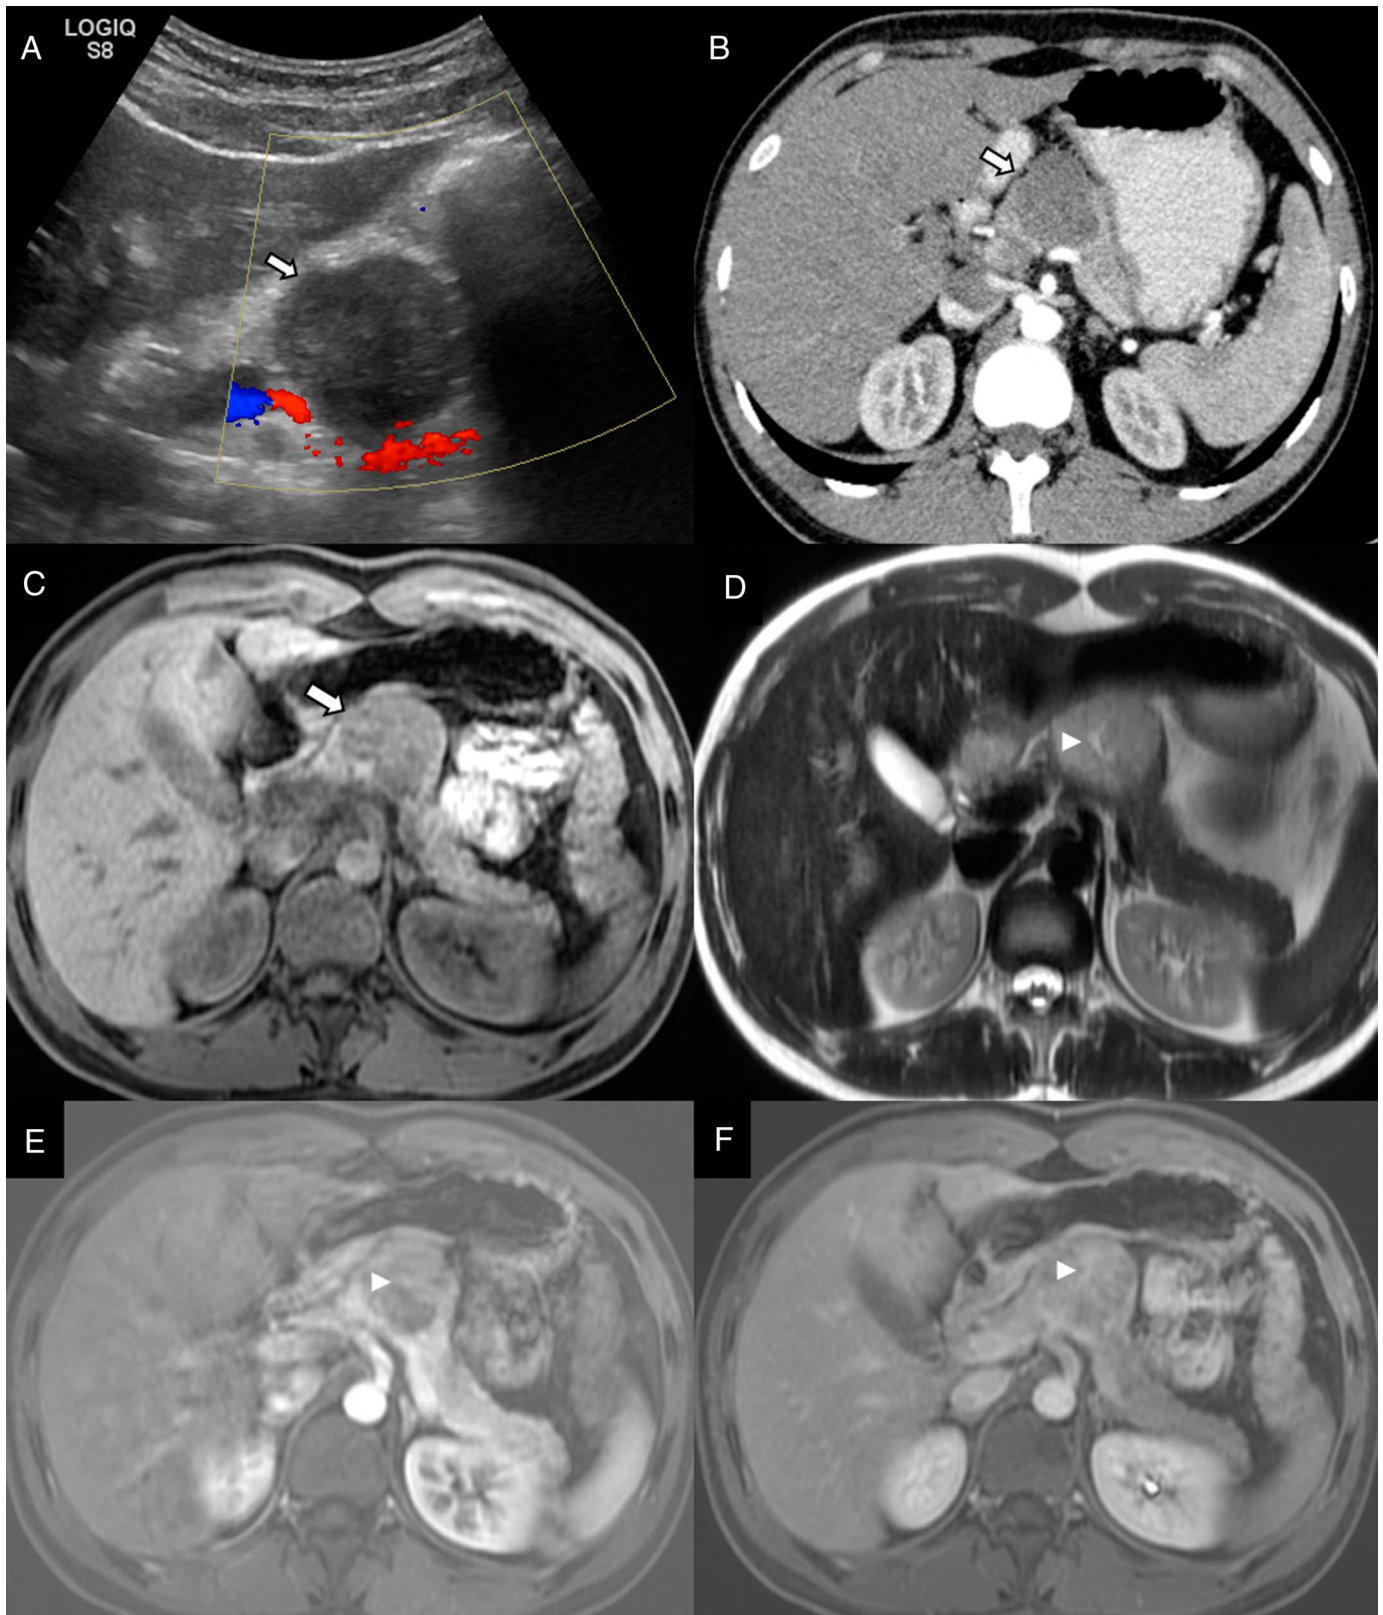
(A) Transverse ultrasound image showing predominantly hypoechoic solid mass lesion (arrow) in the neck of the pancreas without internal vascularity. (B) Axial contrast-enhanced computed tomography arterial phase showing hypoenhancing hypoattenuating lesion (arrow) in the neck of pancreas. (C) Axial T1-weighted magnetic resonance image depicting hypointense lesion (arrow) in the neck of the pancreas. (D) T2-weighted magnetic resonance image showing mildly hyperintense lesion with a central hyperintense scar (arrowhead), (E) minimal enhancement in arterial phase, and (F) gradual delayed enhancement of the central scar (arrowhead) with radiating septae.
